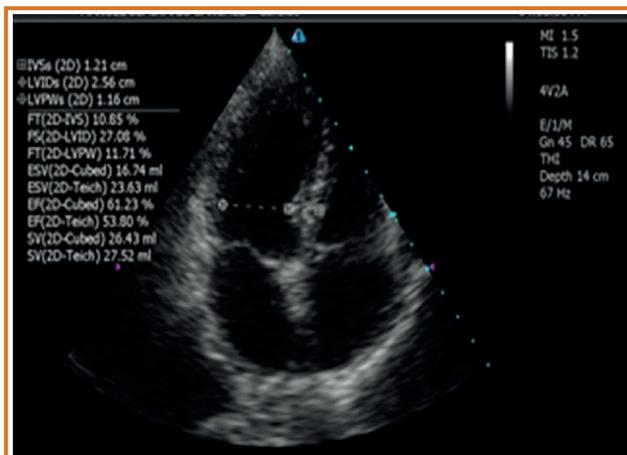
Echocardiographic imaging of the patient. Measurements are taken in a 4-chamber apical view of the left ventricle. Note that there is no dilation, and the hypertrophy is mild.
